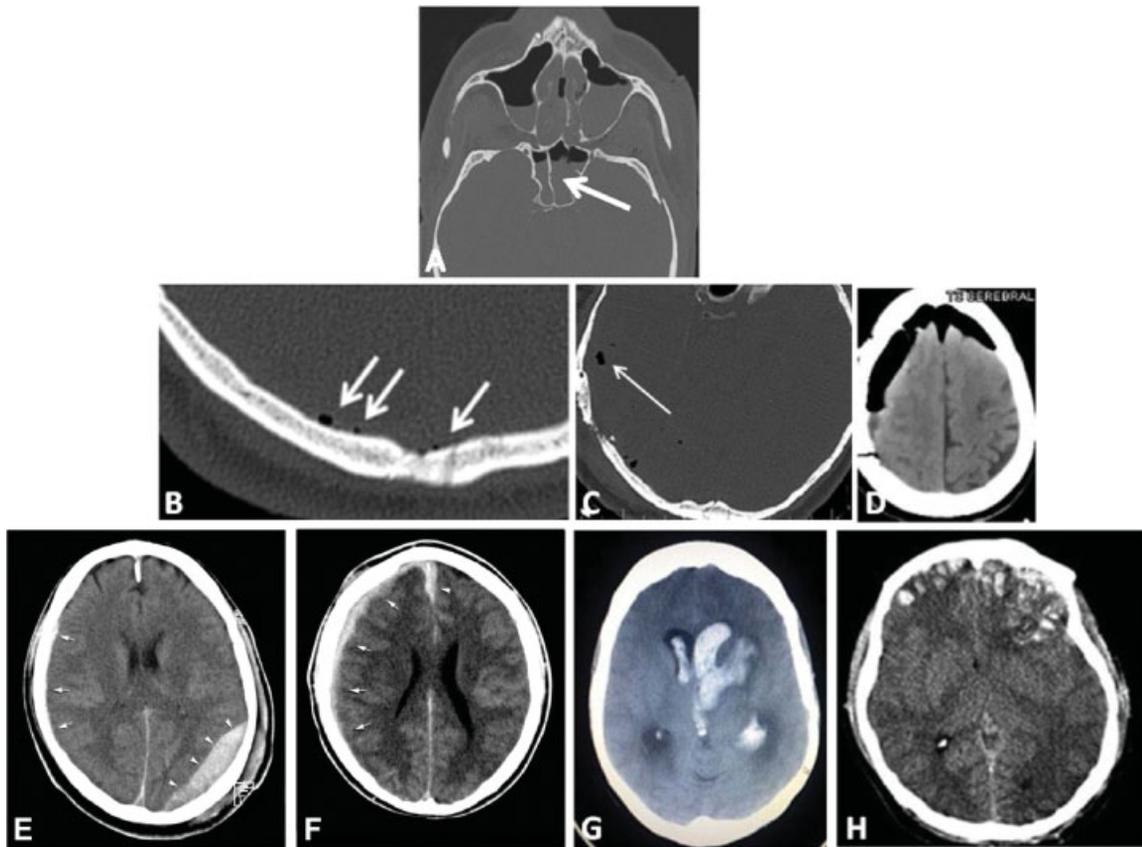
Examples of associated diagnostic features with skull base and cranial vault fractures. (A) Partial opacification in the sphenoid sinus with air–fluid level in computed tomographic imaging (representing possible the presence of blood or fluid). (B–D) Presence of intracranial air: single or multiple air-bubbles in the subdural spaces (arrows in B) or in the subarachnoid space (arrow in C); (D) pneumocephalus. (E–H) Intracranial mass lesions: (E) epidural hematoma in the left occipital region (arrowheads) with small mixed (epidural and subdural) hematomas in the right temporal region (arrows), (F) subdural hematoma of the right hemisphere (arrows) with extension along the falx (arrowhead), (G) intraventricular haematoma, (H) brain contusions.
